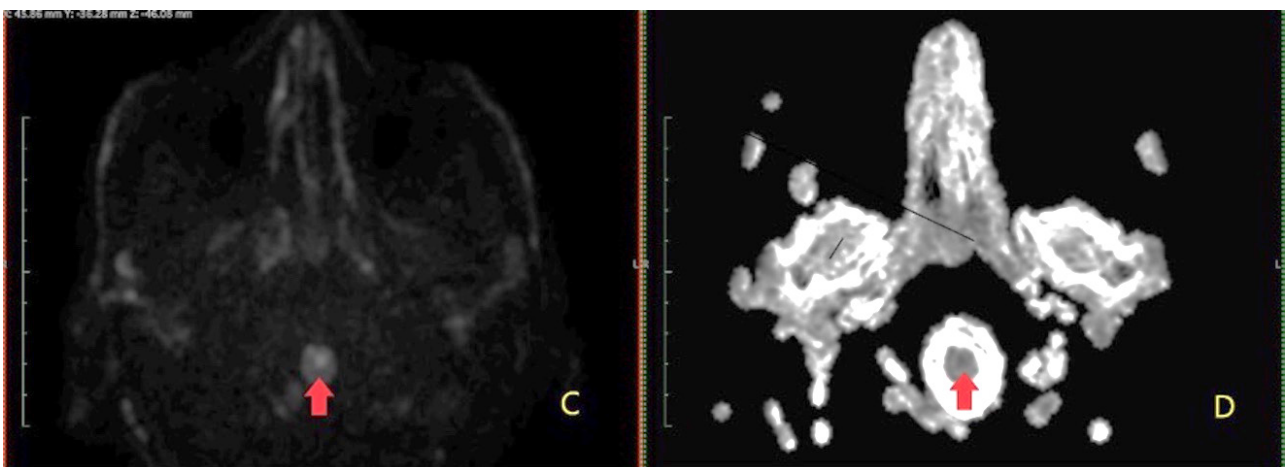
(C) Hyperintense signal on DWI and (D) hypointense signal on ADC (red arrow) at visualized medulla in keeping with abnormal restricted diffusion suggestive of an area of acute infarct.
